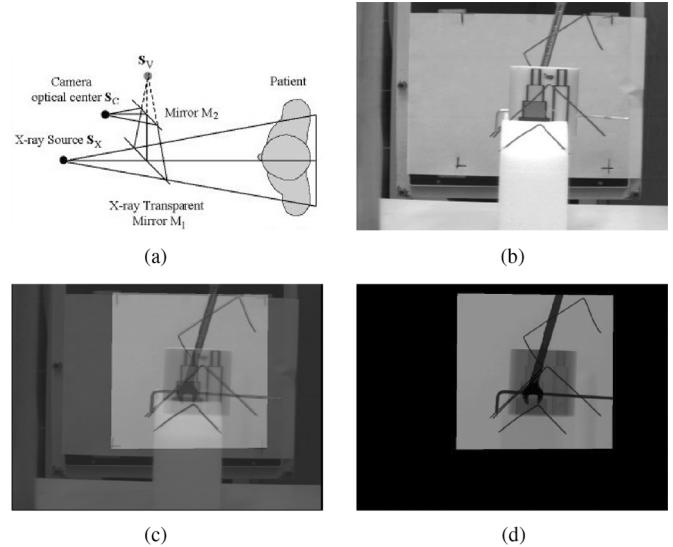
Camera-augmented c-arm (CamC) [78]. © 1999 IEEE. (a) Principle of CamC (CamC), (b) Camera image, (c) fused image, (d) Fluoroscopic X-ray image.
